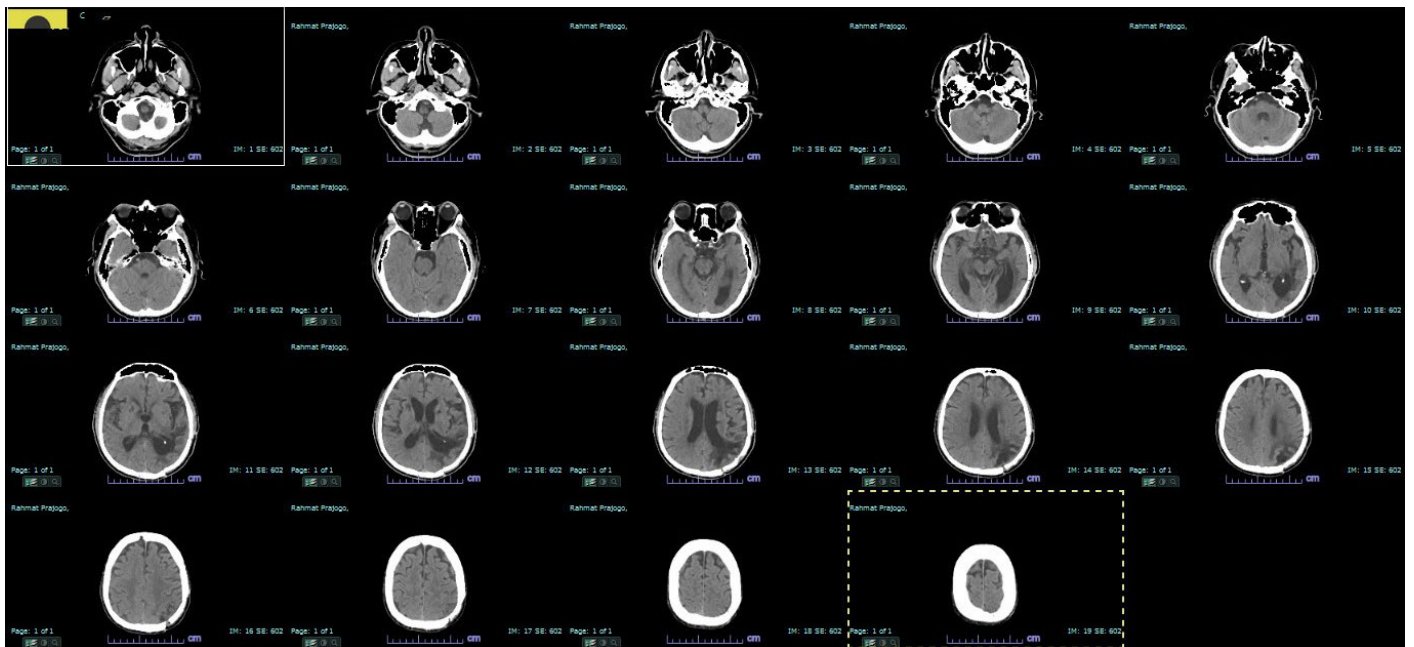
Brain CT scan in March 2023 showing signs of multiple infarction lesions at both side of temporal lobe and left temporooccipital lobe.
